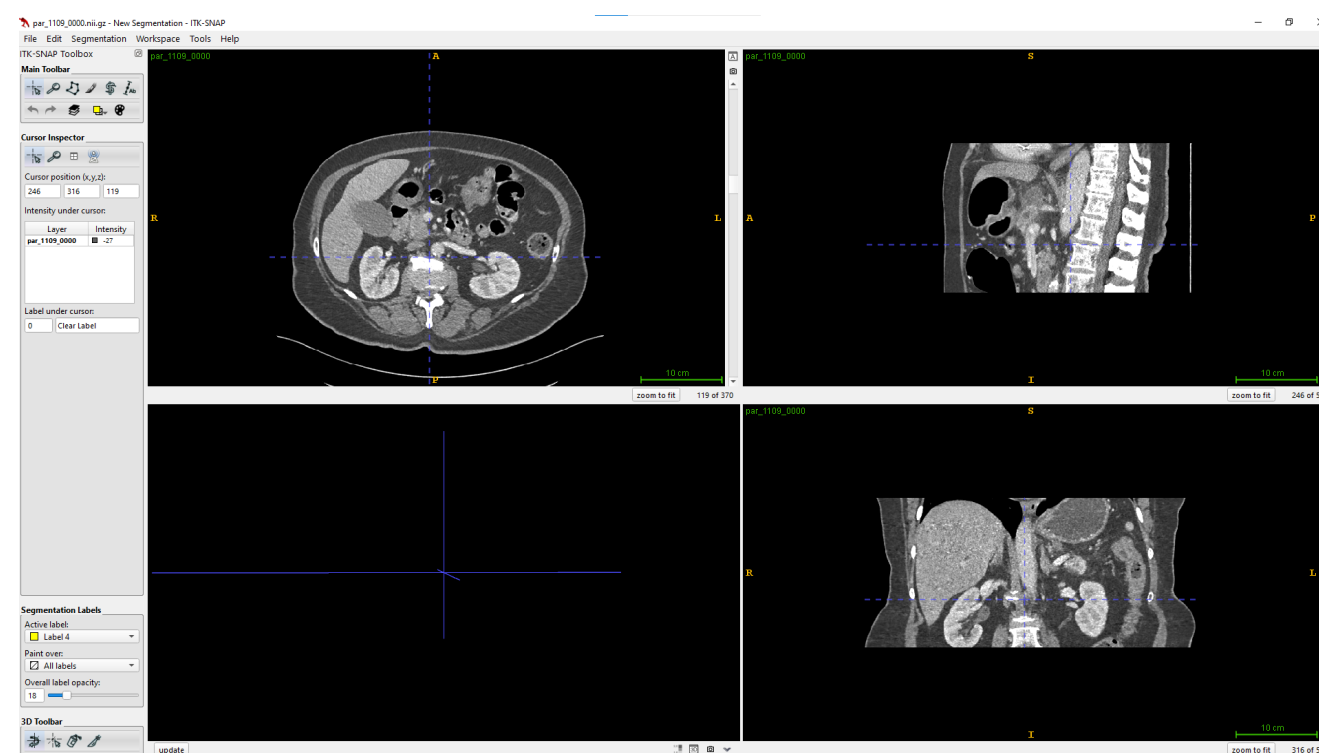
ITK-Snap, a freeware conventional DICOM Viewer A CT scan from different anatomical planes (see Medical Visual Glossary). (Screenshot)
